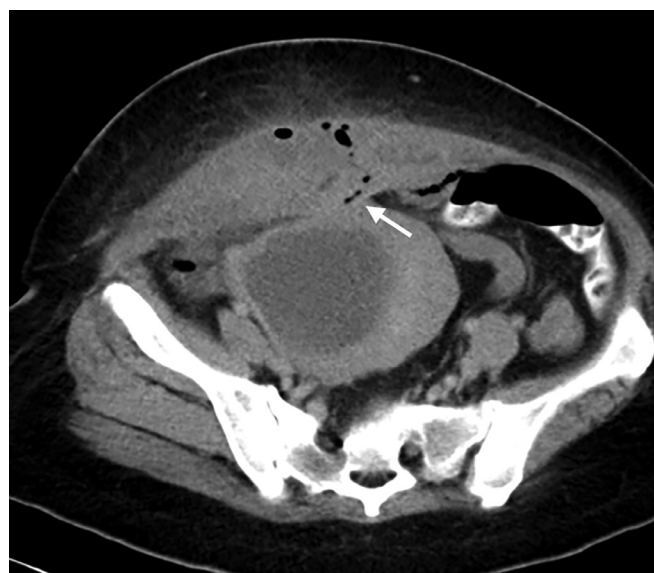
Axial reformatted contrasted CT Abdomen showed another smaller pelvic collection which has a suspicious tiny communication track (white arrow) connecting it to the collections within both rectus abdominis muscles anteriorly. There are associated subcutaneous fat stranding.
